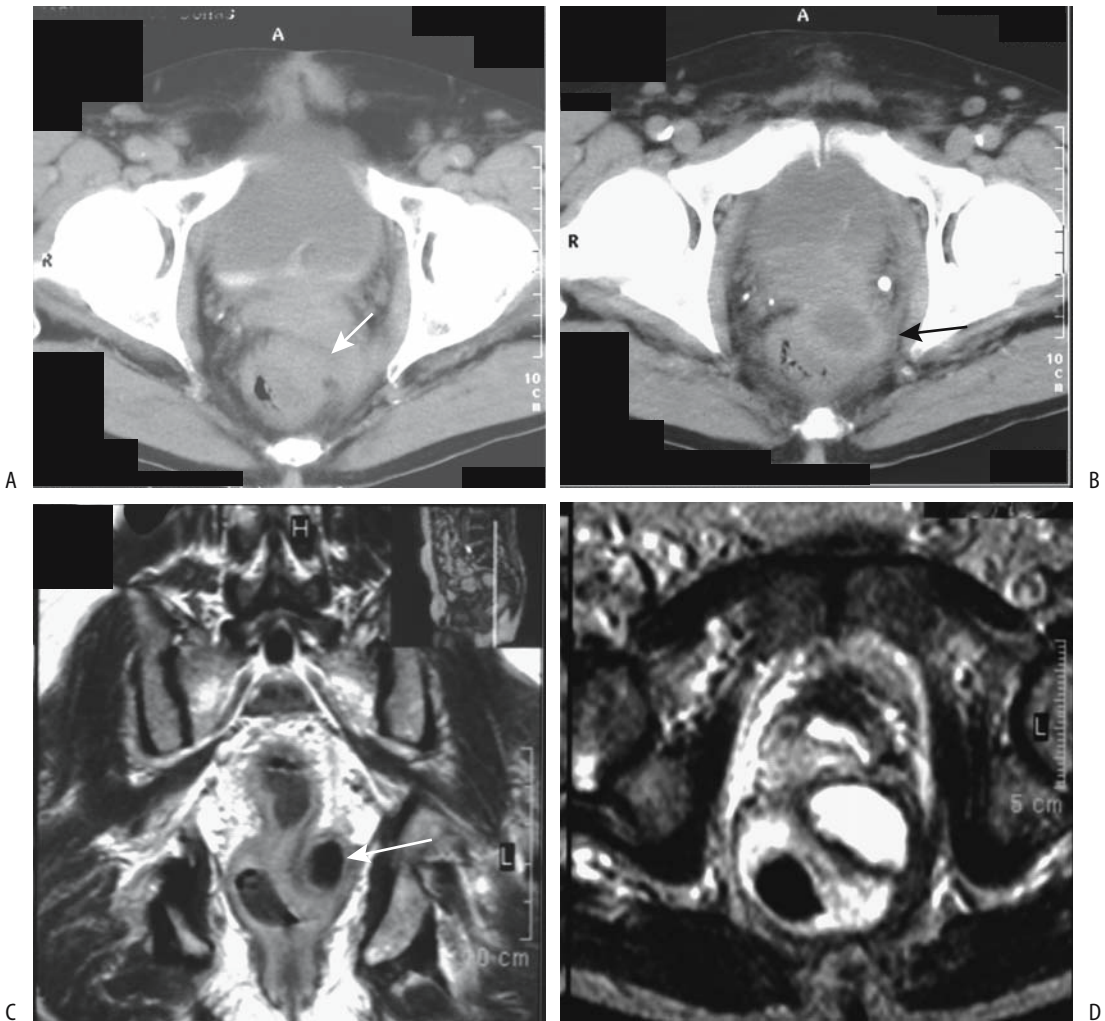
Pararectal abscess mimicking a rectal carcinoma. Constipation developed after prostatic resection 4 months previously for benign hyperplasia. A,B: Two pelvic CT images reveal a rectal tumor narrowing the lumen (arrows). C,D: T1- and T2-weighted images show rectal wall thickening and an adjacent fluid-filled structure (arrow), suggesting an abscess or necrotic tumor. (Courtesy of Egle Jonaitiene, M.D., Kaunas Medical University, Kaunas, Lithuania.)
